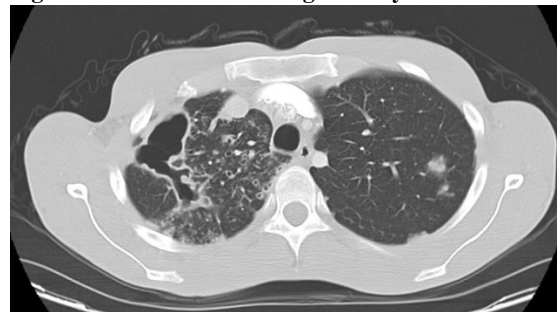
Chest CT scan showing cavitory lesion
